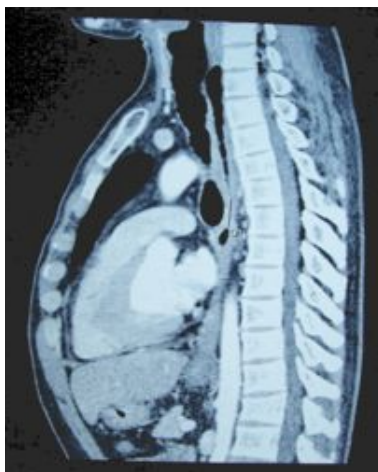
Narrowing of esophageal lumen shown in sagittal view of computed tomography (CT) scan taken in previous hospital
